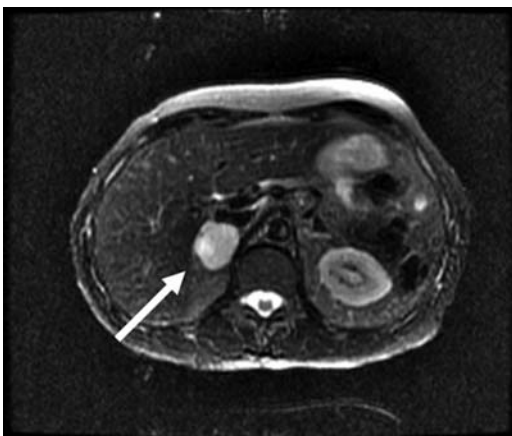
T2-weighted MRI hyperintense pheochromocytoma.
